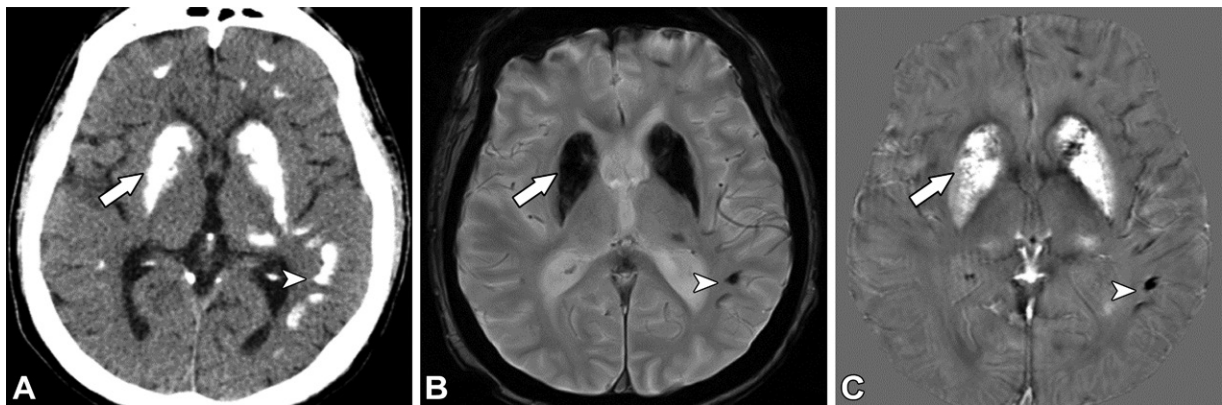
Fahr disease or idiopathic basal ganglia calcification in a 32-year-old man. (A) Axial CT image shows high attenuation of the basal ganglia (arrow) and subcortical area (arrowhead). (B) Axial T2*-weighted MR image shows areas of low signal intensity in the subcortical area (arrowhead) and basal ganglia (arrow). (C) QSM image demonstrates low contrast in the subcortical lesion (arrowhead), indicating calcification, but the basal ganglia demonstrate high contrast (arrow), suggesting mineralization with paramagnetic inorganic substances.
